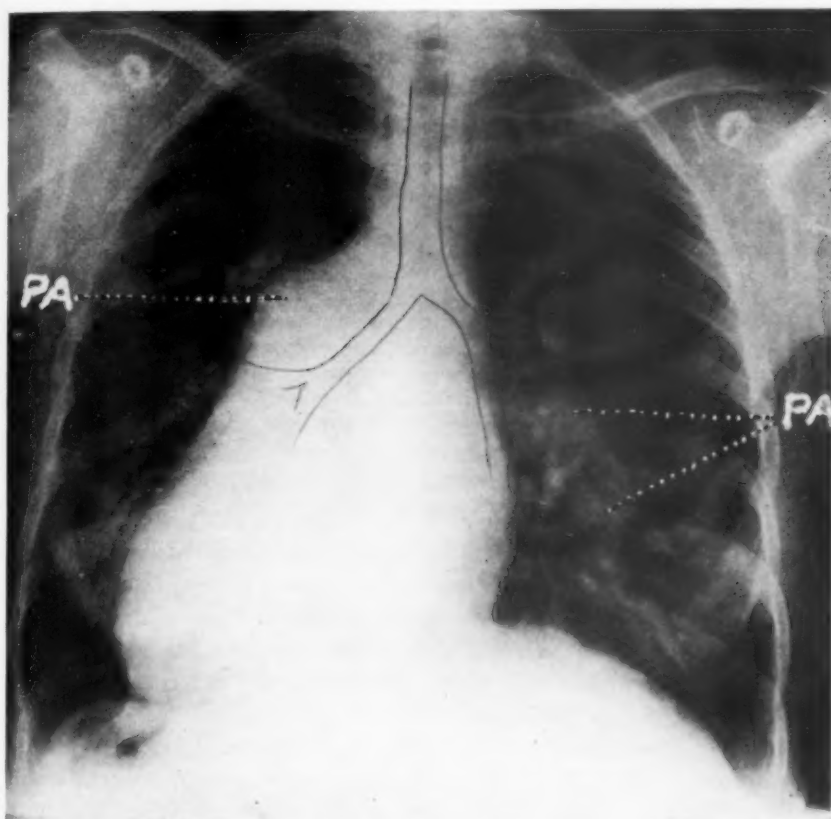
Roentgen-ray of the chest of a case of congenital heart disease showing enlarged and thickened pulmonary arteries on both sides. Relationship to main bronchi is shown.
